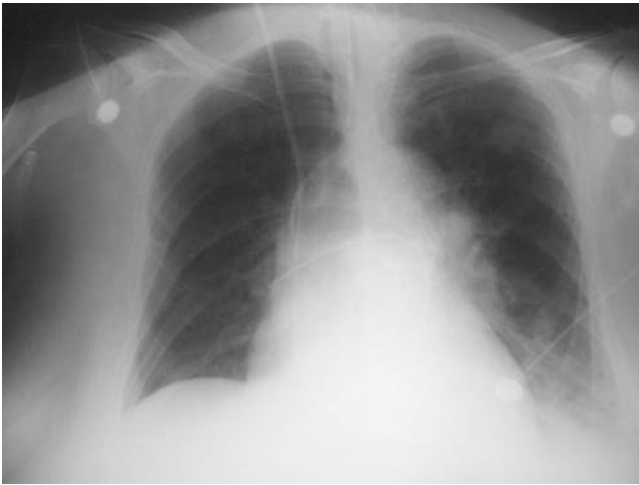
Chest X-ray 3 days after the event, when the patient's condition had significantly improved
